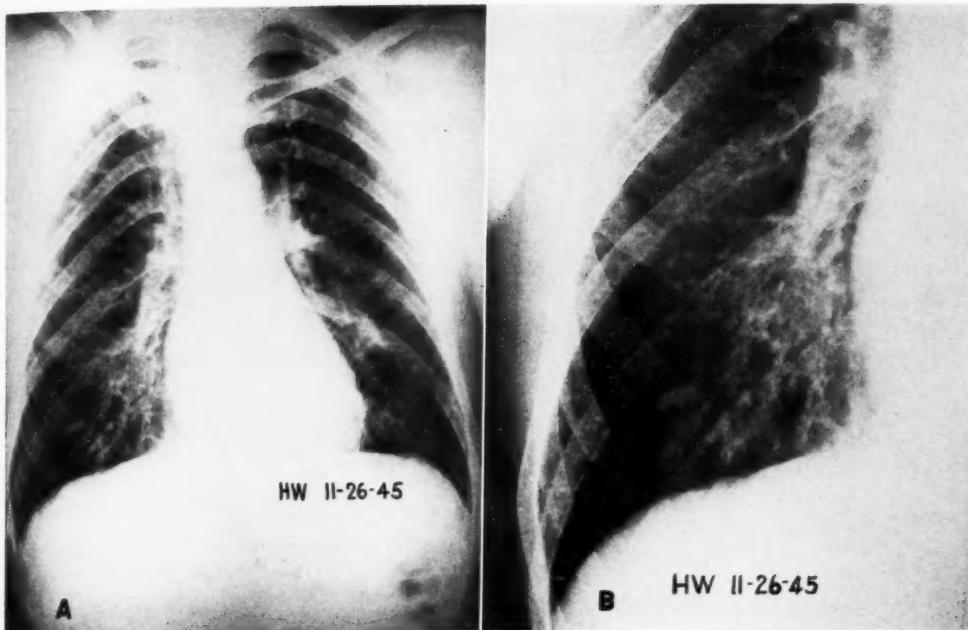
Case II. A. Chest roentgenogram with bilateral patchy consolidation. Dilated basal interlobular septa are present bilaterally, more marked on the right.
